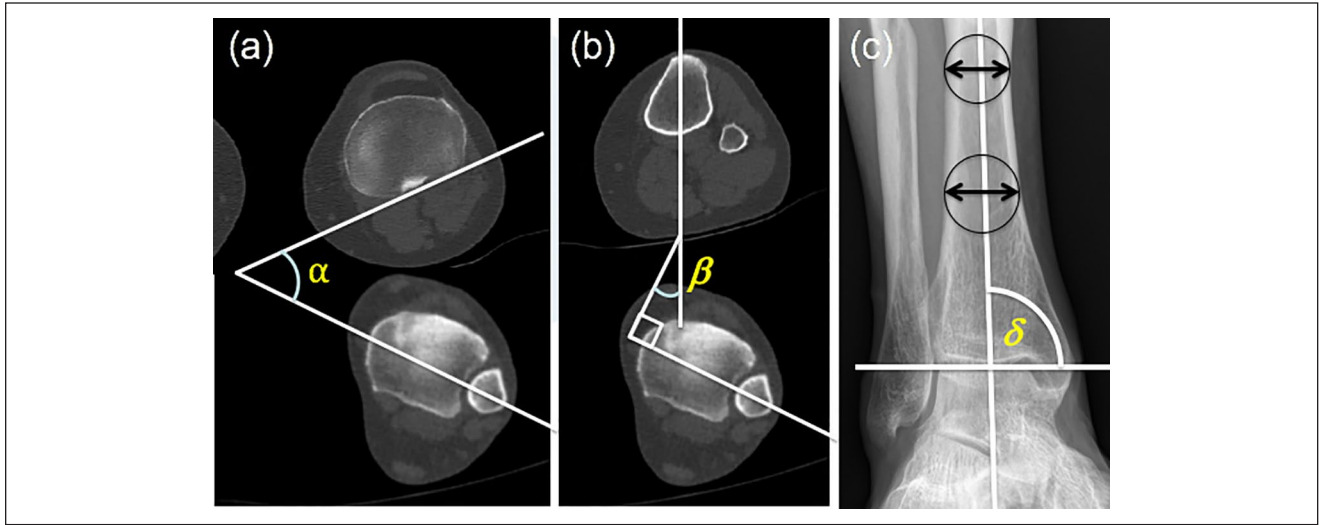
Axial computed tomography scans at a cross section of the knee and ankle used to calculate tibial torsion. (A) Tibial torsion is defined as the angle between the line connecting both posterior condyles of the tibia and the line bisecting the articular surfaces of the medial and lateral malleoli (the transmalleolar axis [TMA]) (α). (B) The middle picture demonstrates the angle between a line drawn along the most prominent point of the medial third of the tibial tuberosity, and the TMA (β). (C) Measurement of the tibiotalar angle on plain radiographs. The center point of the medial and lateral margins of the diaphysis of the tibia was plotted at 2 points of the diaphysis and a circle was drawn. A central line was drawn connecting these 2 points, and this was called the anatomical axis of the tibia. A separate line was drawn along the top of the articular surface of the talus. The medial angle was calculated to give the tibiotalar angle (δ).
